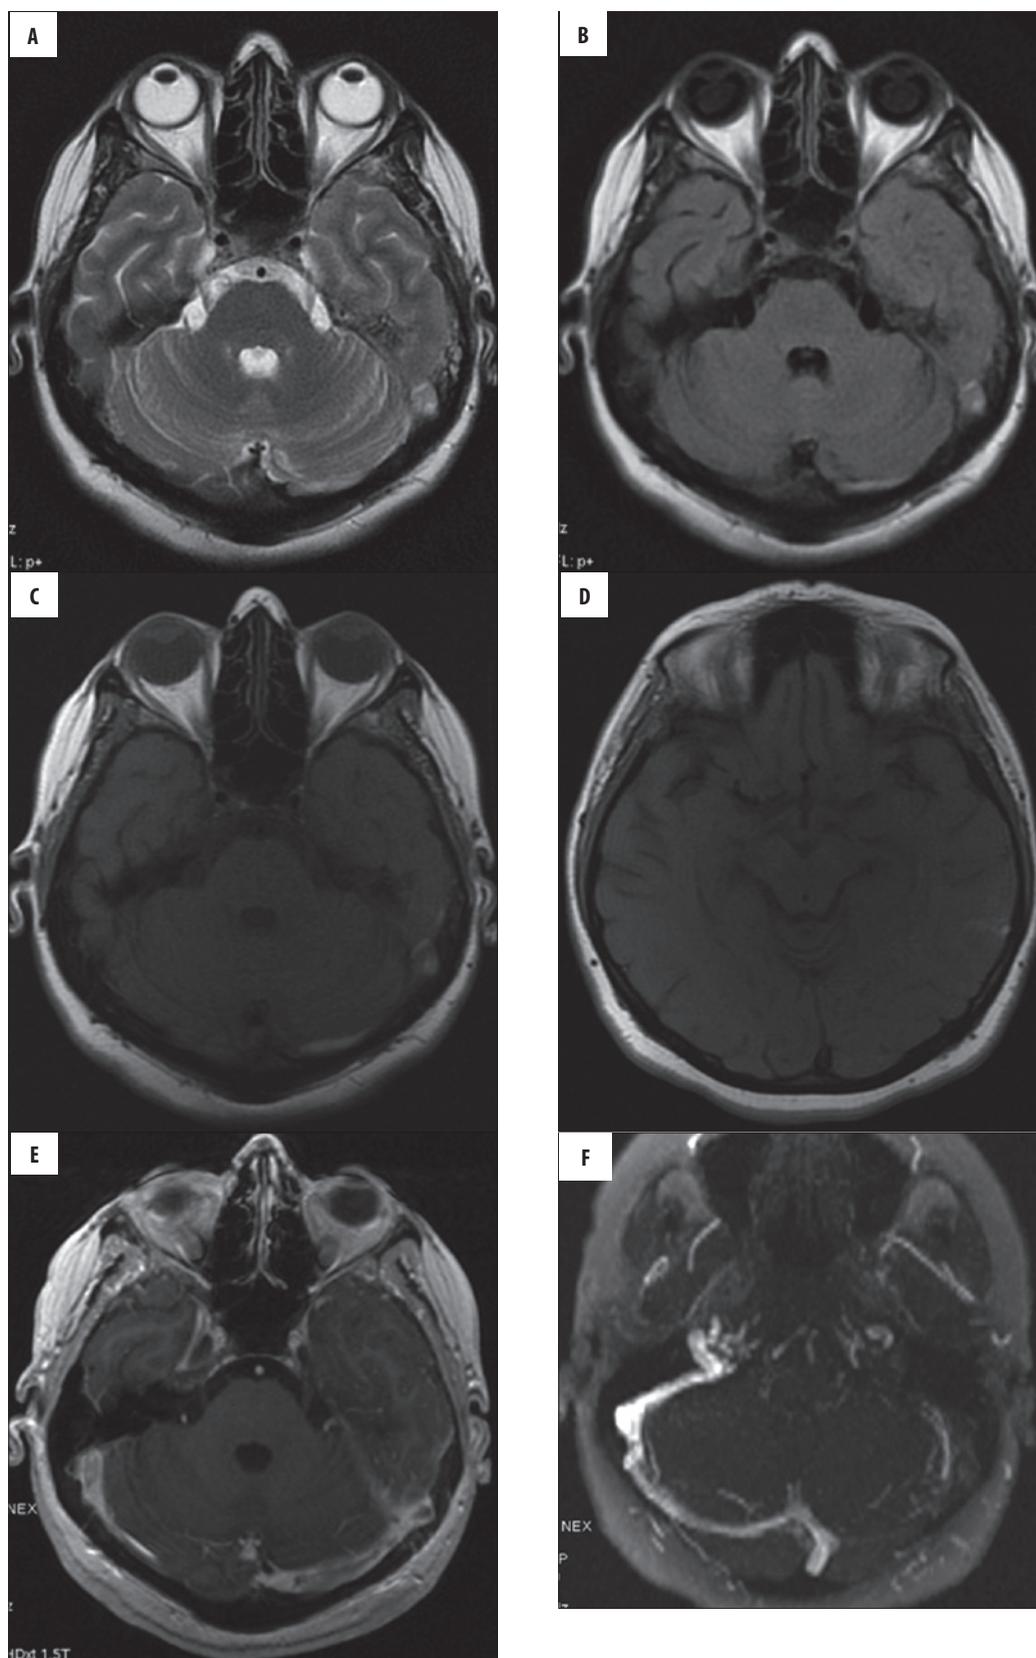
Patient with cerebral venous thrombosis. Changes within cerebral veins in MRI: (A) – T2-, (B) – FLAIR, (C, D) – T1-weighted images, (E) – contrast enhanced T1-weighted image, (F) – MR venography without contrast injection. Thrombosed left transverse sinus is seen as hyperintense on T1, T2 and FLAIR images (A–C), as well as filling defect after contrast injection (E) or loss of signal in MR venography (F). Thrombosed left vein of Labbe is also visible as hyperintense dot on T1-weighted image (D).
